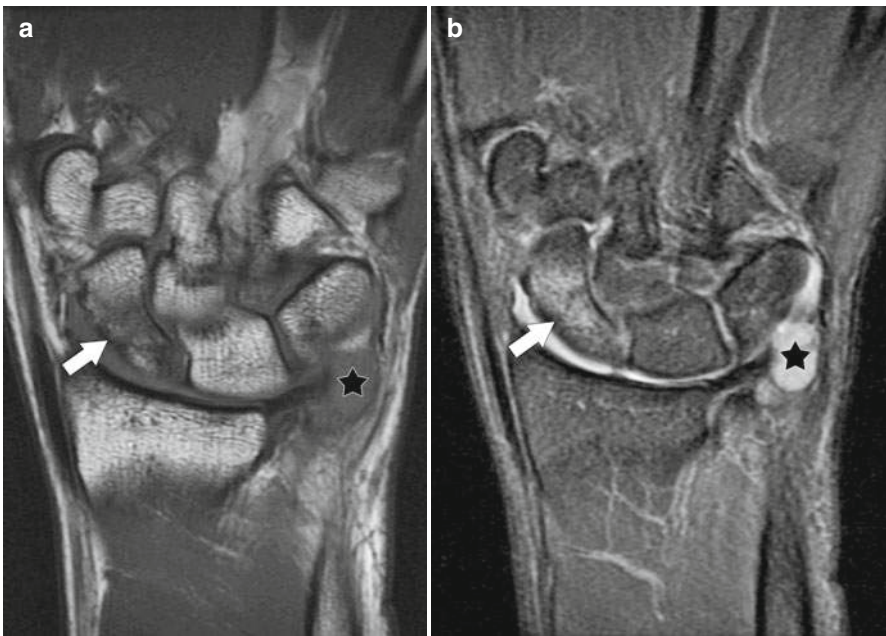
Scaphoid fracture. Wrist MR T1- (a) and T2-weighted (b) images in a patient with negative wrist X-rays reveals abnormal linear signal in the scaphoid (arrows). A joint effusion (star) is also noted
